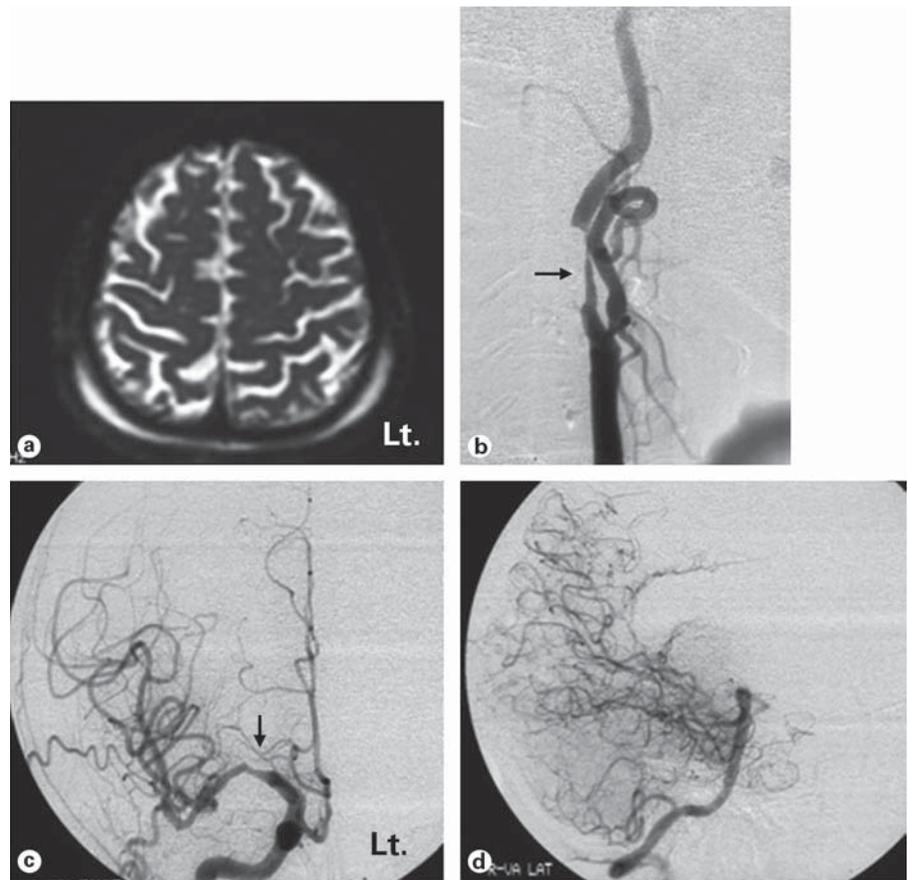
Pre-operative evaluation of case 2. a MRI (T₂WI) which showed no infarction in SM1. b DSA of right carotid artery at the cervical bifurcation (lateral view) showing 85% stenosis (arrow) on NASCET measurement. c DSA of right intracranial ICA (lateral view), presenting stenosis of right middle cerebral artery (arrow mark). d DSA of right vertebrobasilar artery (lateral view), showing cortical anastomosis from posterior cerebral artery into the right MCA territory.
